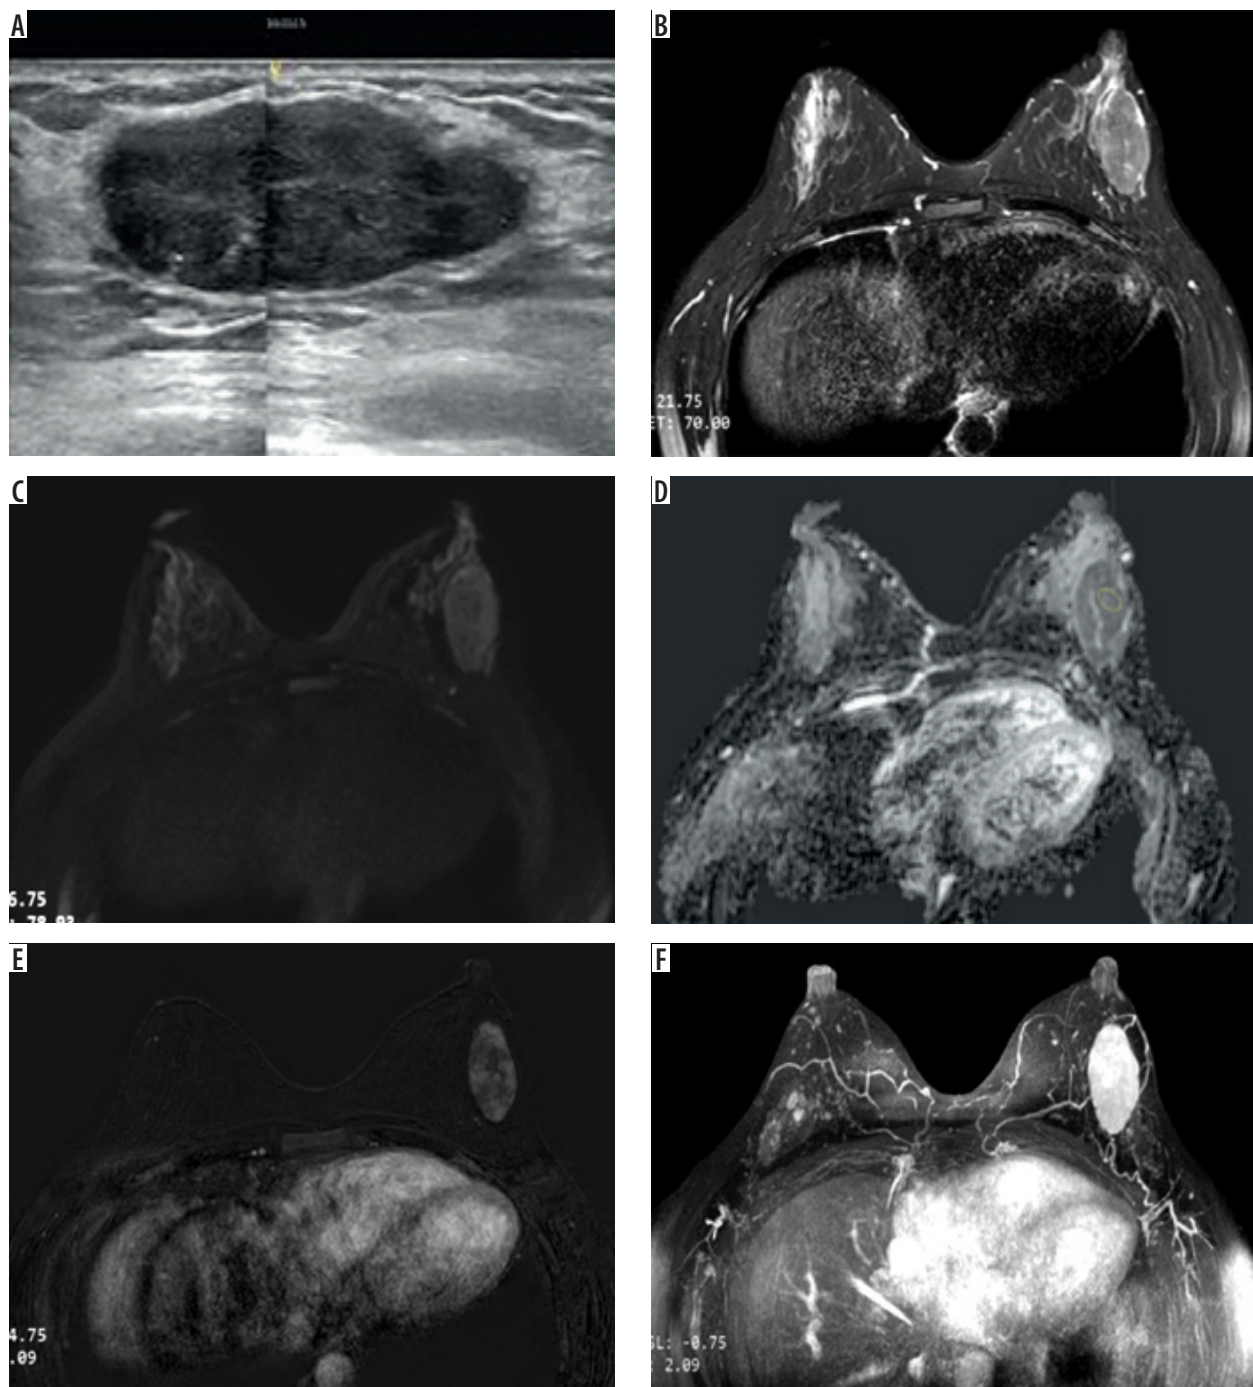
A 44-year-old woman with pathologically confirmed fibroadenoma. Ultrasonography (US) (A) shows a hypoechoic nodule (Breast Imaging Reporting and Data System [BI-RADS] 3). Magnetic resonance imaging (MRI) demonstrates mild hyperintensity on T2-weighted imaging (T2WI) (B), slight hyperintensity on diffusion-weighted imaging (DWI) (C) with apparent diffusion coefficient (ADC) value of $1.25 \times 10^{-3} \text{ mm}^2/\text{s}$ (D), heterogeneous enhancement on first post-contrast subtracted (FAST) (E), and hyperintensity on maximum-intensity projection (MIP) (F). The lesion was correctly classified as negative (BI-RADS < 4) by full diagnostic protocol MRI (FDP-MRI), non-contrast abbreviated MRI (NC-AMRI), and dynamic contrast-enhanced abbreviated MRI B (DCE-AMRI B), but was misinterpreted as positive by DCE-AMRI A alone. NC-AMRI: T2WI + DWI (B + C); DCE-AMRI A: FAST + MIP (E + F); DCE-AMRI B: FAST + MIP + DWI (C + E + F)
